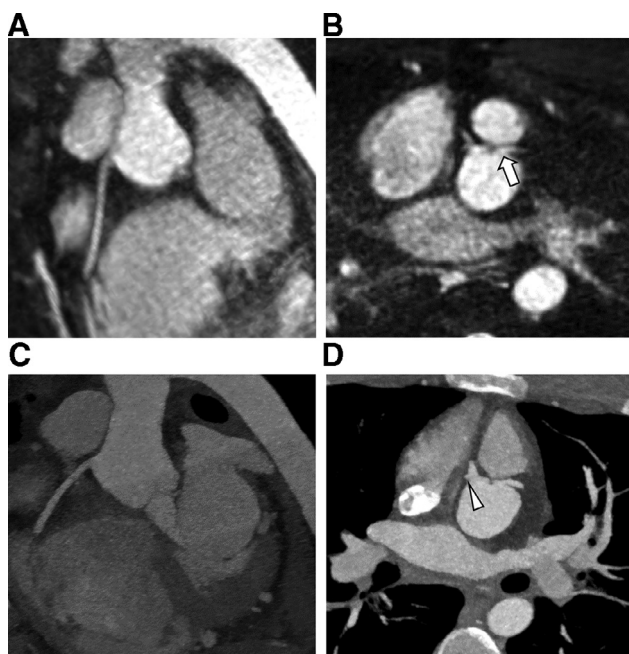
Noncontrast self-navigated 3D coronary magnetic resonance angiography (SN3D-MRA, A and B) with corresponding coronary computed tomographic angiography (CTA) (C and D) acquired in a 14-year-old boy status-post surgical correction of transposition of the great arteries. Both imaging tests reveal a high origin of the re-implanted right (RCA) and left main coronary artery (LM). Both MRA and CTA visualize the atypical origin of the left circumflex coronary (LCX) from the RCA (arrowhead). Furthermore, the LM is slightly compressed between ascending aorta and main pulmonary artery (arrow). Thus, the relevant diagnostic information regarding proximal CA anatomy is provided by MRA without ionizing radiation or the need for contrast-media administration. However, image quality was rated higher for CTA.
